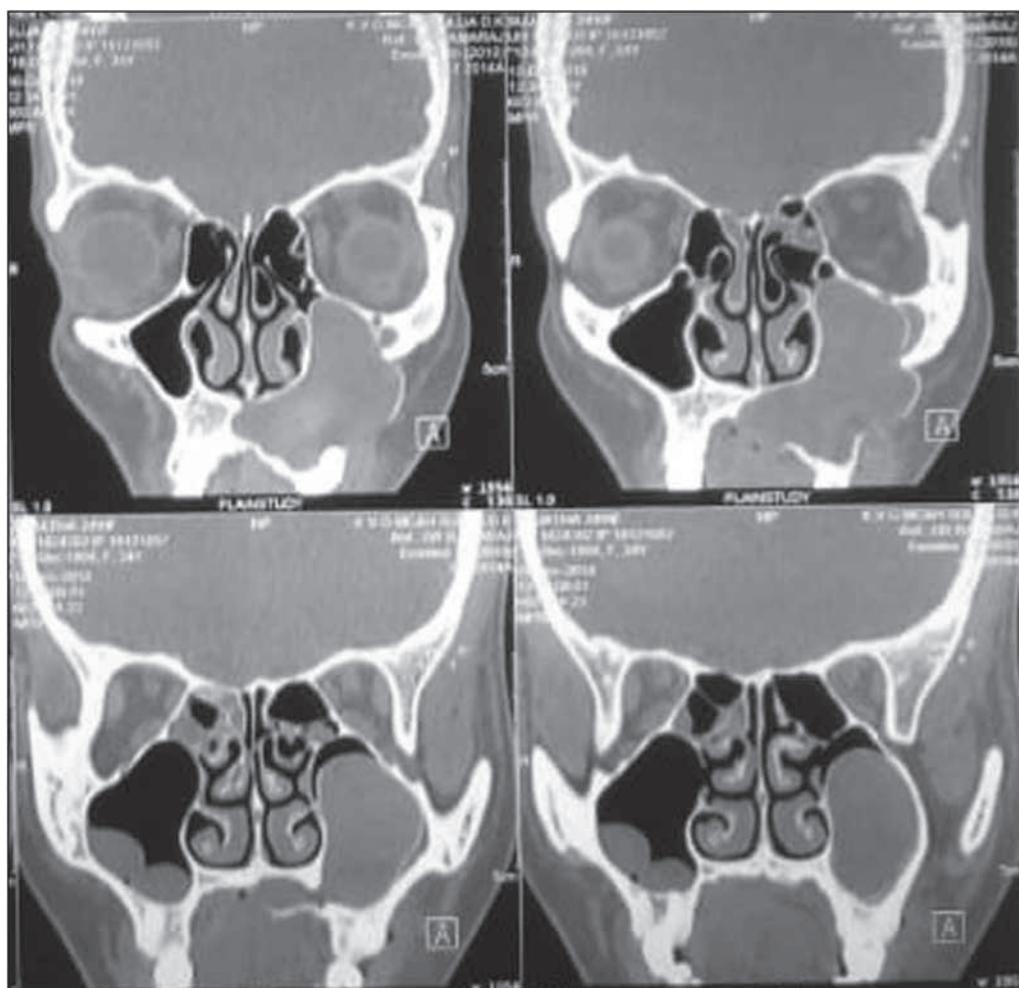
Computed tomography PNS shows a radiopaque lesion extending into the antrum along with the erosion of the anterolateral wall of maxillary sinus and palatal roof. PNS = paranasal sinus view
